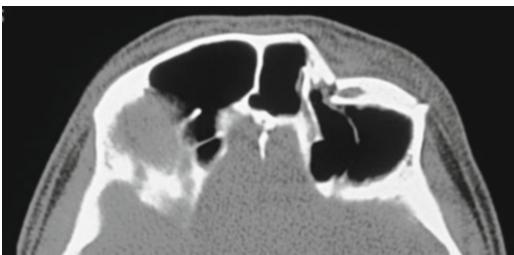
The axial CT image taken of the patient shows the fragments of the lateral wall of the frontal sinus
